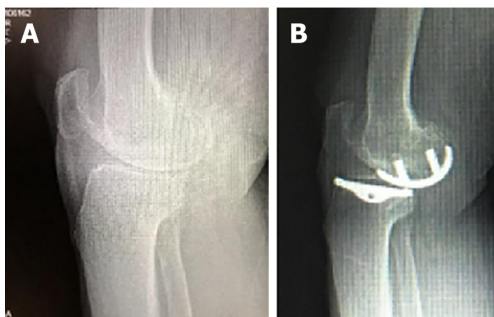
Treatment process (right knee) for Patient 9. A: Lateral X-ray before unicompartmental knee arthroplasty (UKA); B: Lateral X-ray in the weight-bearing position after UKA.
